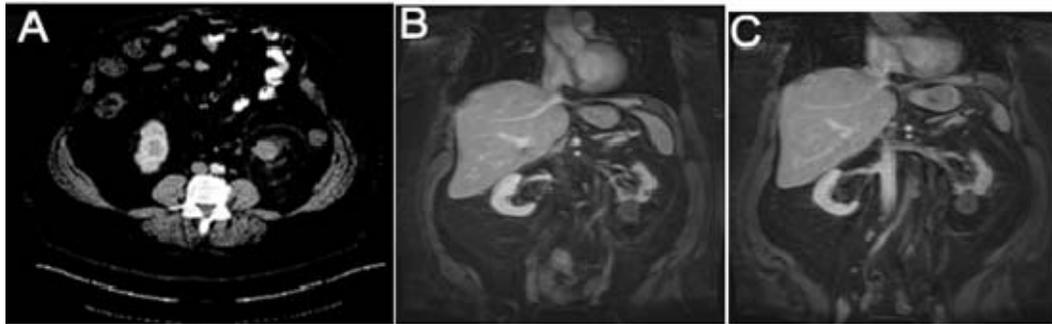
A. CT scan performed 1 month , B. MRI performed after 5 months, C. MRI performed after 13months reveals a non-enhancing post ablative changes in the lower pole of the left kidney
